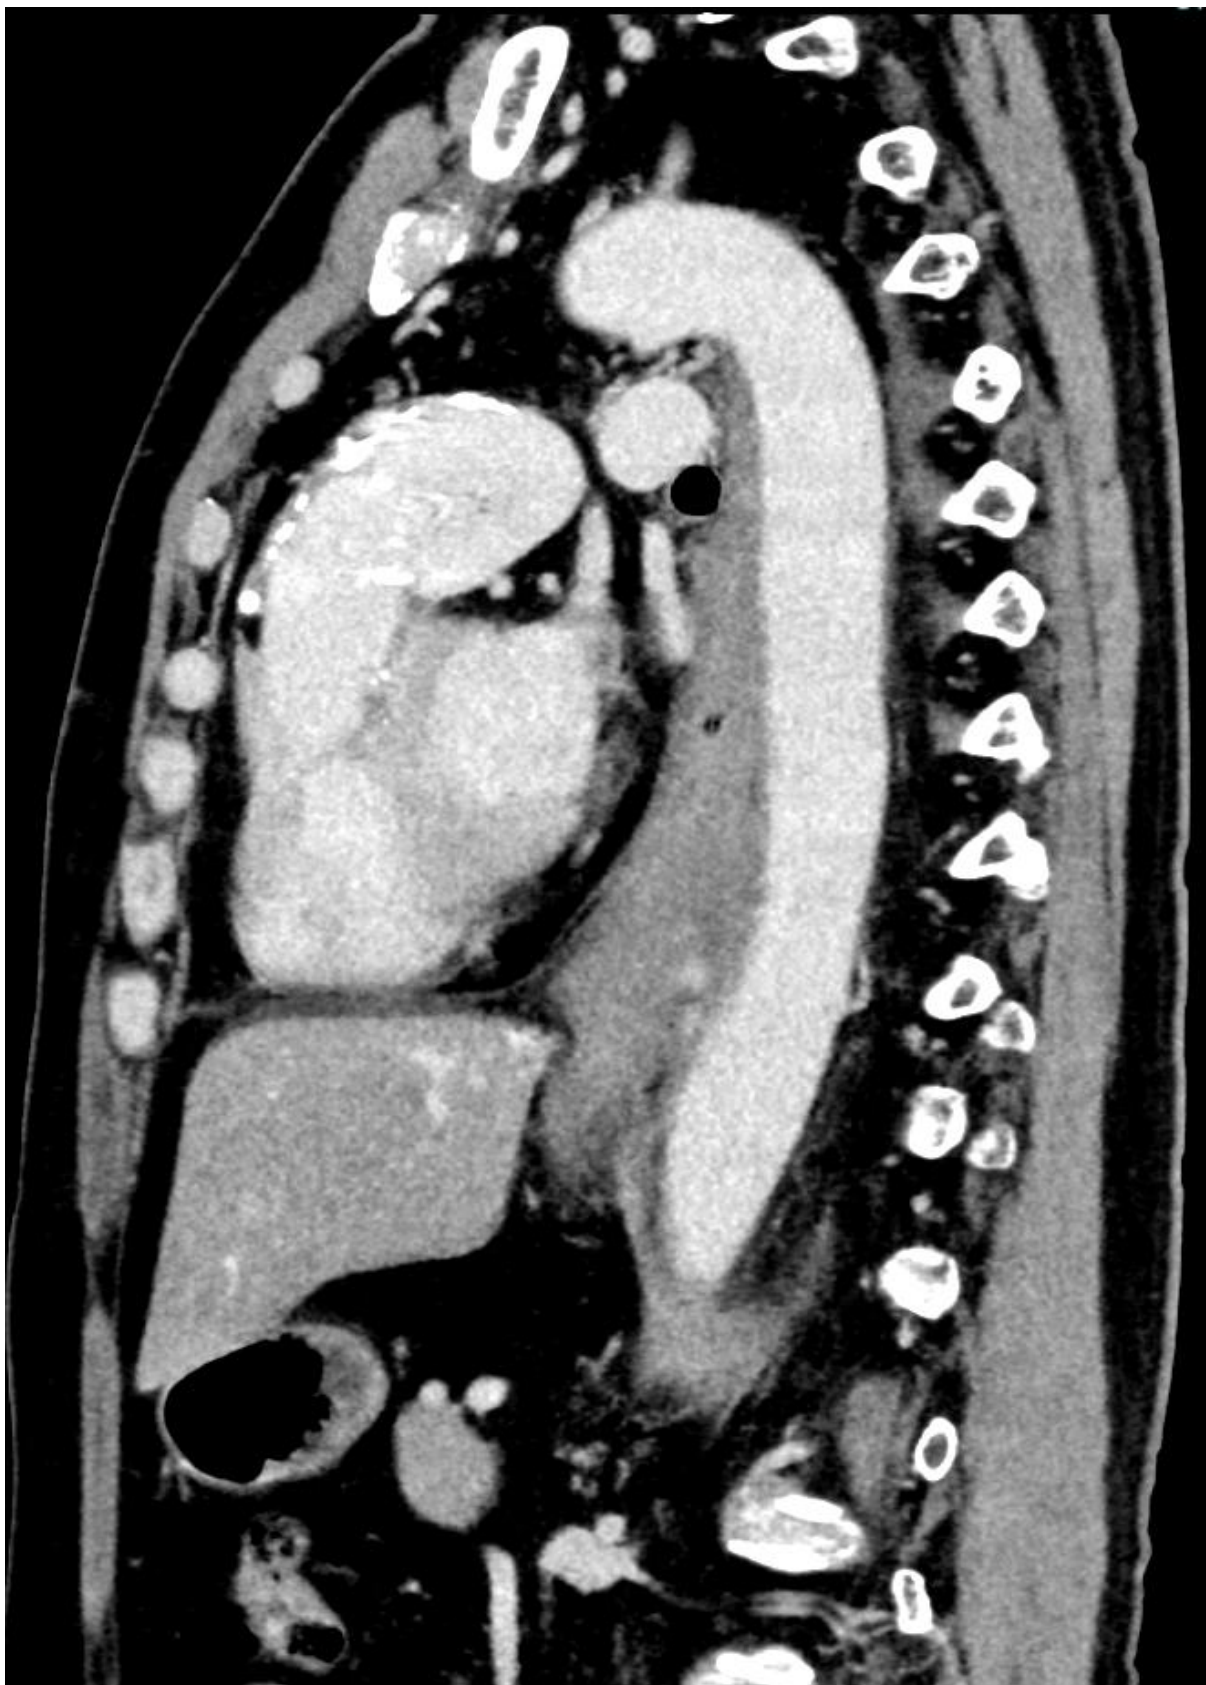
An enhanced computed tomography scan at the onset shows a massive hematoma in the inferior mediastinum. Emphysema is not observed within the mass (A). Mediastinal hematoma exists along ventral side of the descending aorta. The mass is large in the lower mediastinum and gradually decreases in size toward the upward (B).
